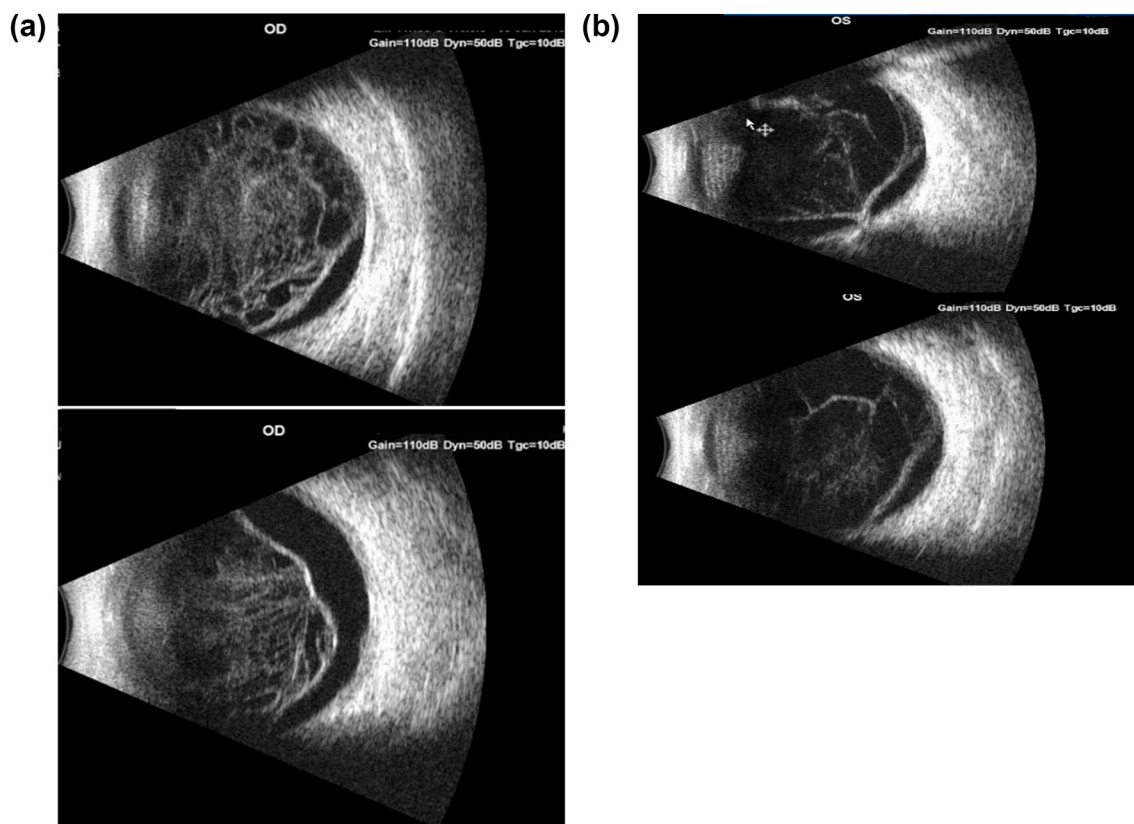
Ultrasound at presentation of the right and left eyes showing moderate-to-dense vitreous opacities with vitreal membrane formation.
